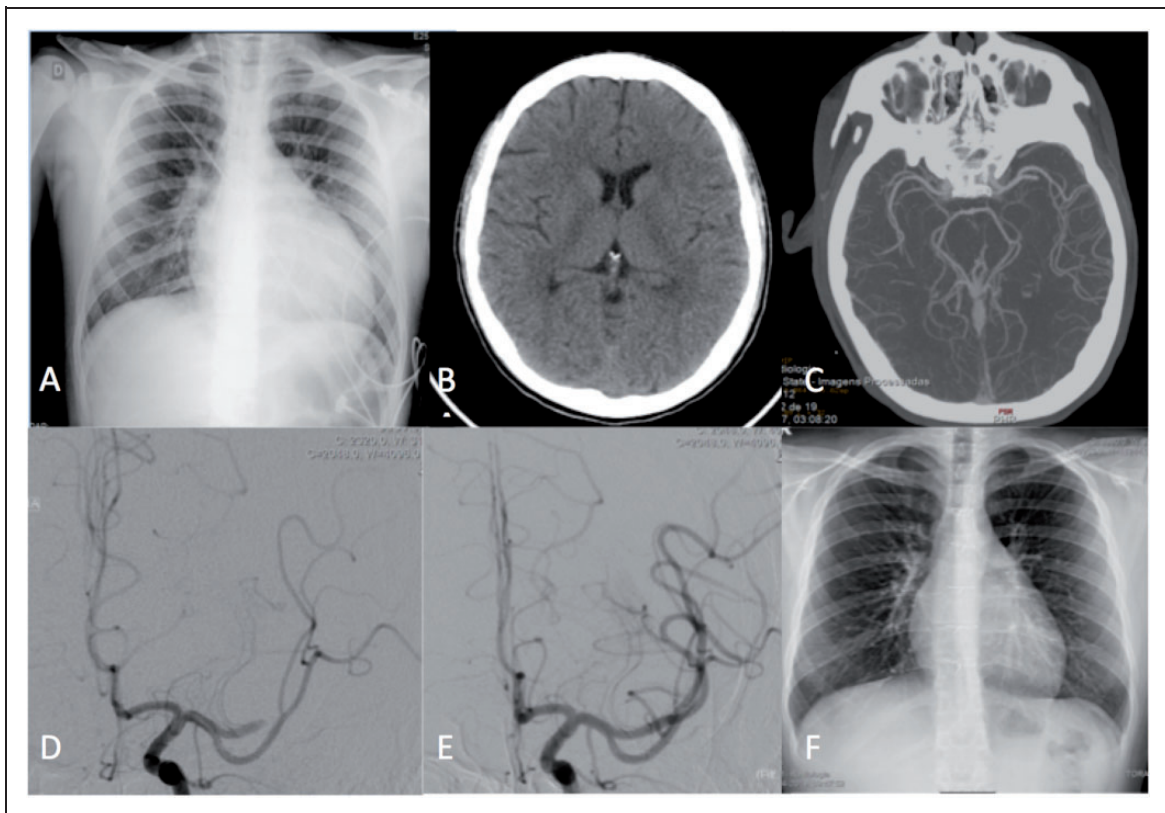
A 13-year-old patient presented with acute aphasia and right hemiparesis. The patient was under cardiac external assistance, on a cardiac transplant list after myocarditis and cardiac failure. Chest radiography showed an increased cardiothoracic index (a). CT scan performed 4 hours after onset of symptoms showed no lesion (ASPECTS 10) (b), and a left M2 occlusion on CT angiography (c). The patient was transported to the angio suite, and thrombectomy was started at 7h30m after symptom onset. Occlusion of the anterior division of the left MCA was confirmed (d), and the clot was aspirated, with complete recanalization (e). The patient recovered completely, and had a cardiac transplant some weeks after. Follow up chest radiography showed normal cardiac dimensions (f).
